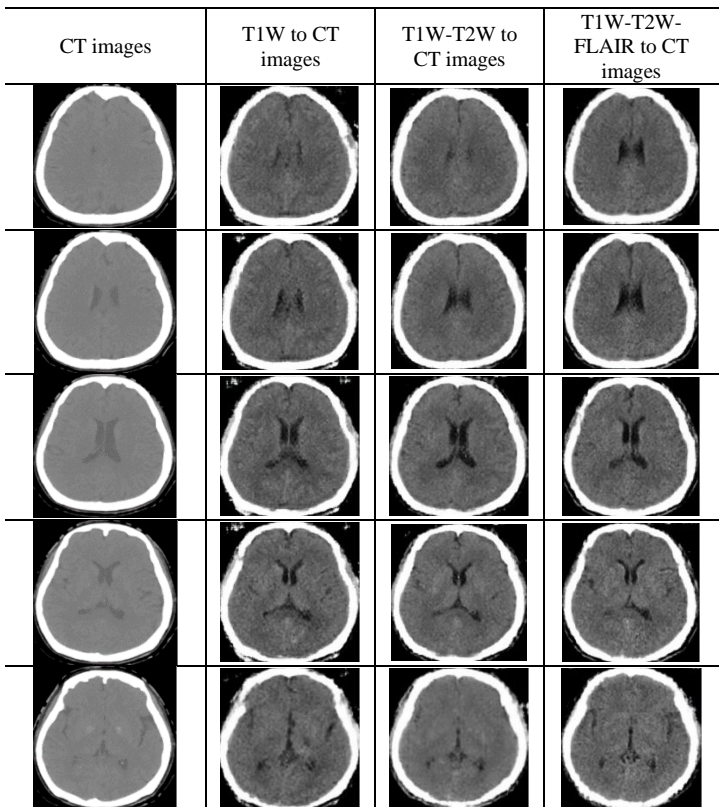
Sample translation results of Patient#2. The actual CT images (1st column), translated CT images from T1W (2nd column), T1W-T2W (3rd column), T1W-T2W-FLAIR images (4th column).
